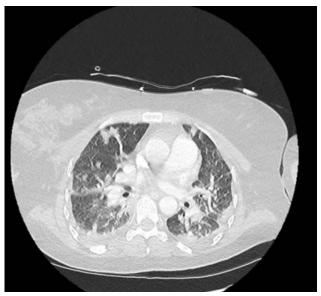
Admission CT-Thorax demonstrating multifocal airspace opacities in keeping with multifocal pneumonia. The quality of the images is unfortunately affected by respiratory motion artefact.
